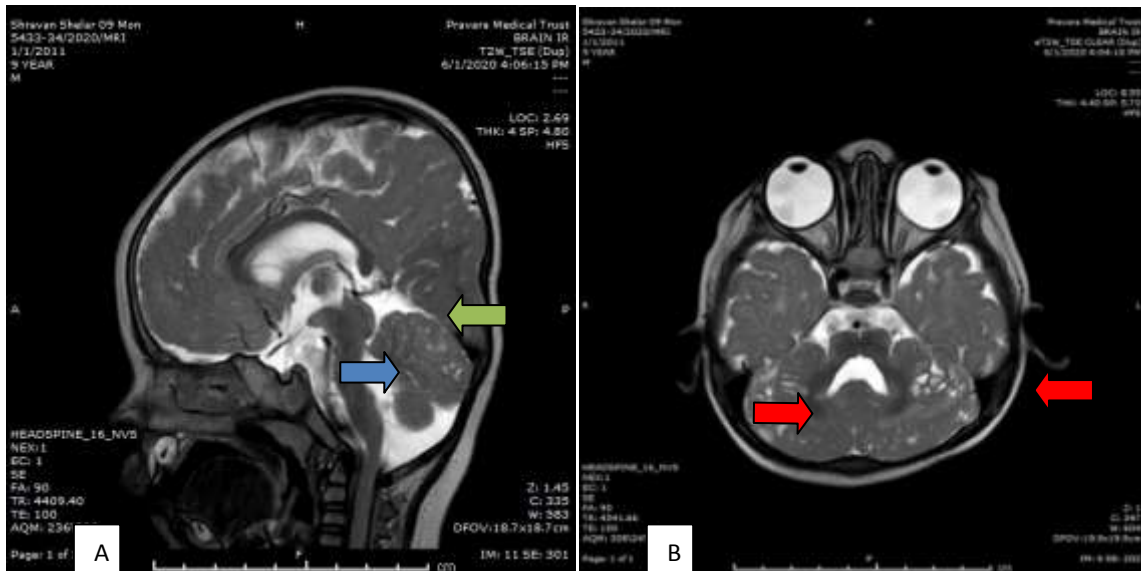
(A) MRI sagittal T2 images showing pontine hypoplasia (blue arrow), enlarged fourth ventricle, and fusion of superior and inferior colliculi (green arrow) (B) Axial T2 image shows lateral cerebellar cysts (red arrows).
